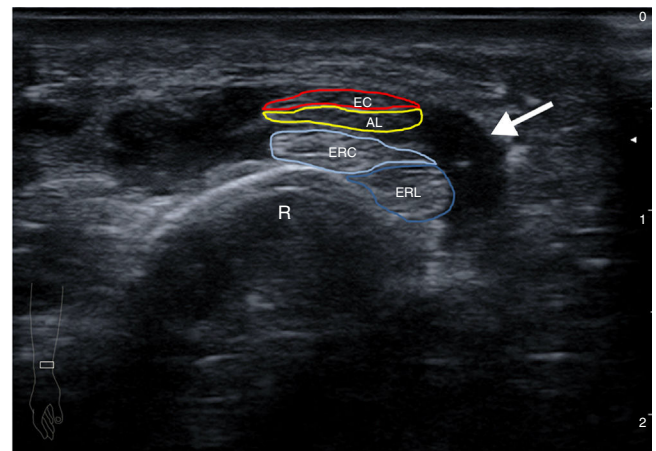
Transverse ultrasound image of the distal region of the right forearm. Showing tenosynovitis (arrow) of the tendons of the I and II extensor compartment as they cross. AL: abductor longus of the first finger; EB: extensor brevis of the first finger; ECRB: extensor carpi radialis brevis; ECRL: extensor carpi radialis longus; R: radius.
